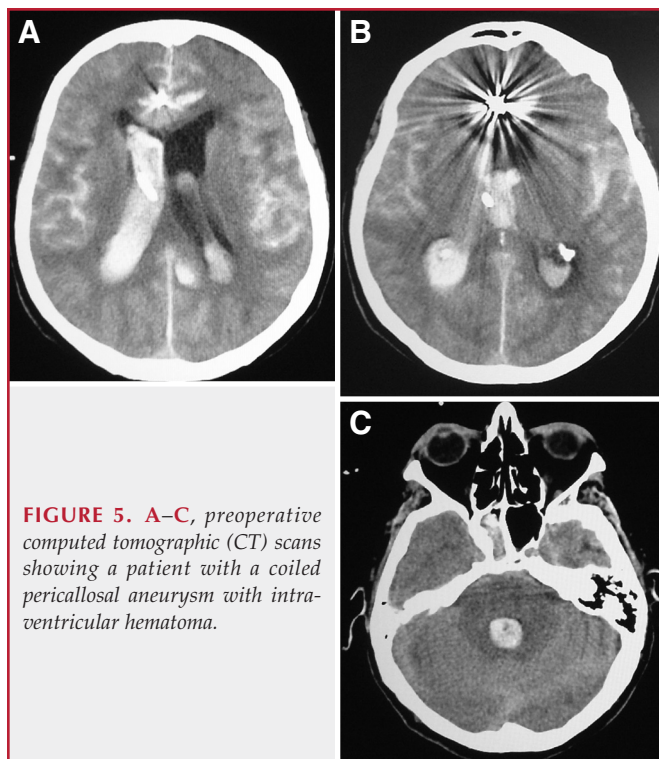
A–C, preoperative computed tomographic (CT) scans showing a patient with a coiled pericallosal aneurysm with intraventricular hematoma.
